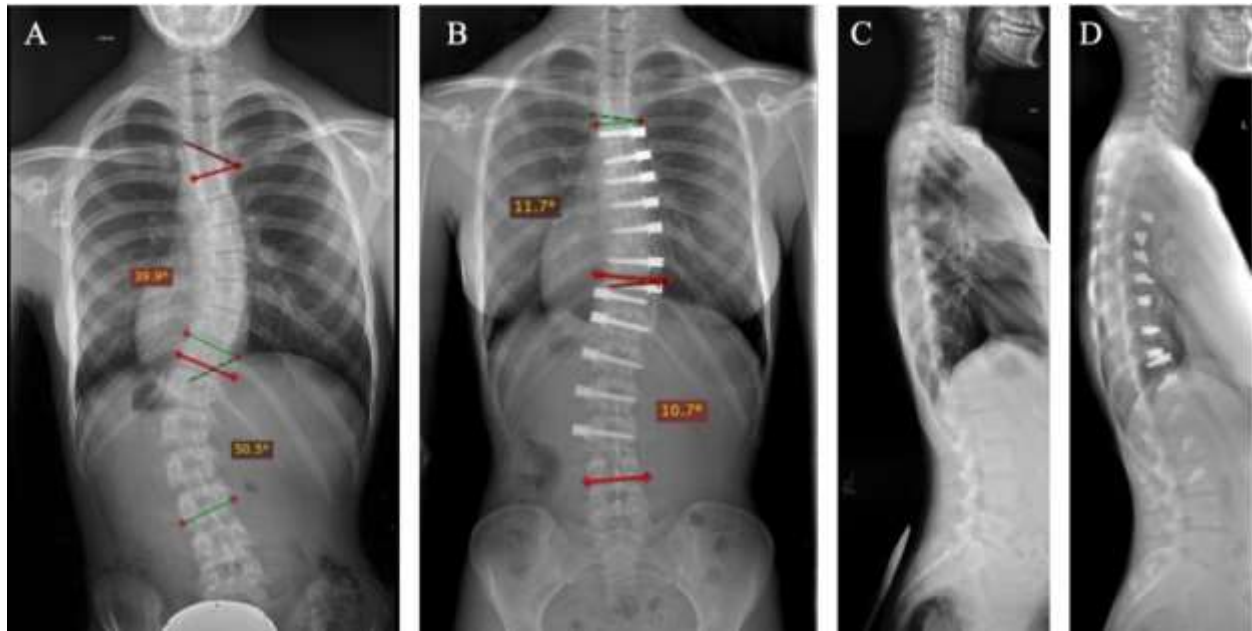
(A) Preoperative and (B) 50-month PA radiographs of 13-year-old girl (Risser 3, Sanders 5) with AIS who underwent ASC with no disc releases. Patient demonstrated preoperative curves of 40° (thoracic) and 51° (lumbar). Curves were 12° (thoracic) and 11° (lumbar) at 50-month follow-up. 3D kyphosis (C & D) improved from 4° preoperatively to 21° post operatively. There was suspected cord breakage at 3 levels (T9/10, T10/11, and L2/3) which occurred by 2-year follow-up with no further loss of correction.
